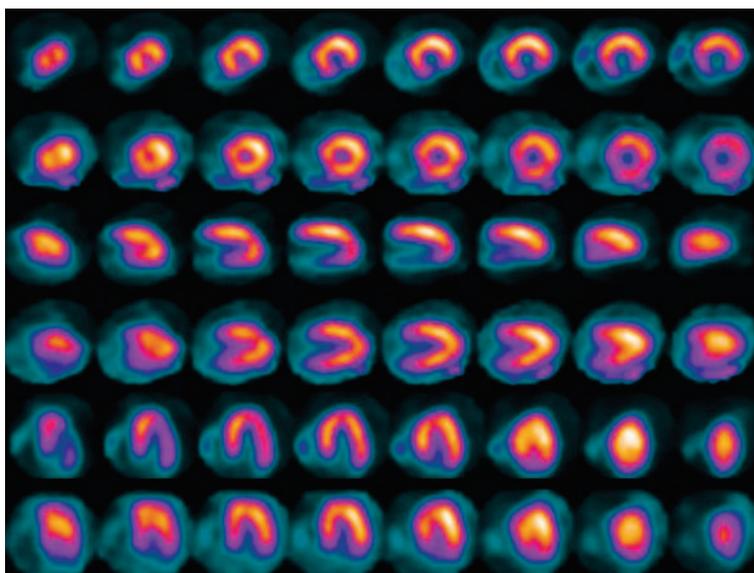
Exercise single photon emission computed tomography (SPECT) images from a patient who underwent stenting of the left anterior descending coronary artery 8 months previously. At the time of stent implantation, non-obstructive disease was evident in the mid left circumflex artery. The patient was asymptomatic until 2 weeks before stress testing. There is a medium-sized, severe, reversible perfusion defect involving the inferolateral wall of the left ventricle. Perfusion appears normal in the left anterior descending artery territory. The patient underwent repeat coronary angiography. The lesion in the mid left circumflex artery was found to have progressed to 90% diameter stenosis; the left anterior descending artery stent was patent.
